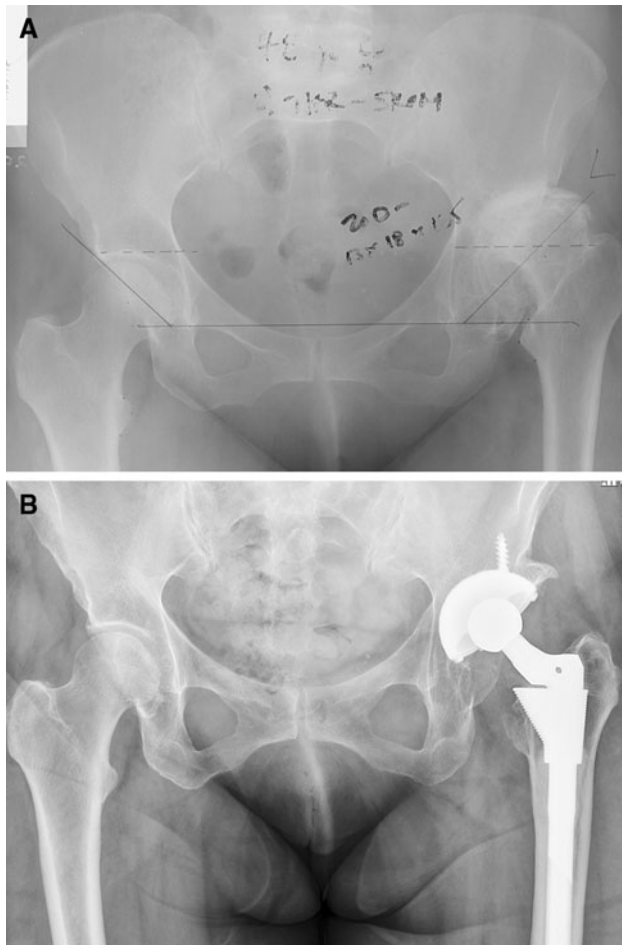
B (A) AP preoperative radiograph of a 49-year-old woman with Crowe II hip dysplasia. (B) Postoperative radiograph 16 years later showing an uncemented THA at a high hip center with osseointegration of the cup and no evidence of wear or osteolysis.
